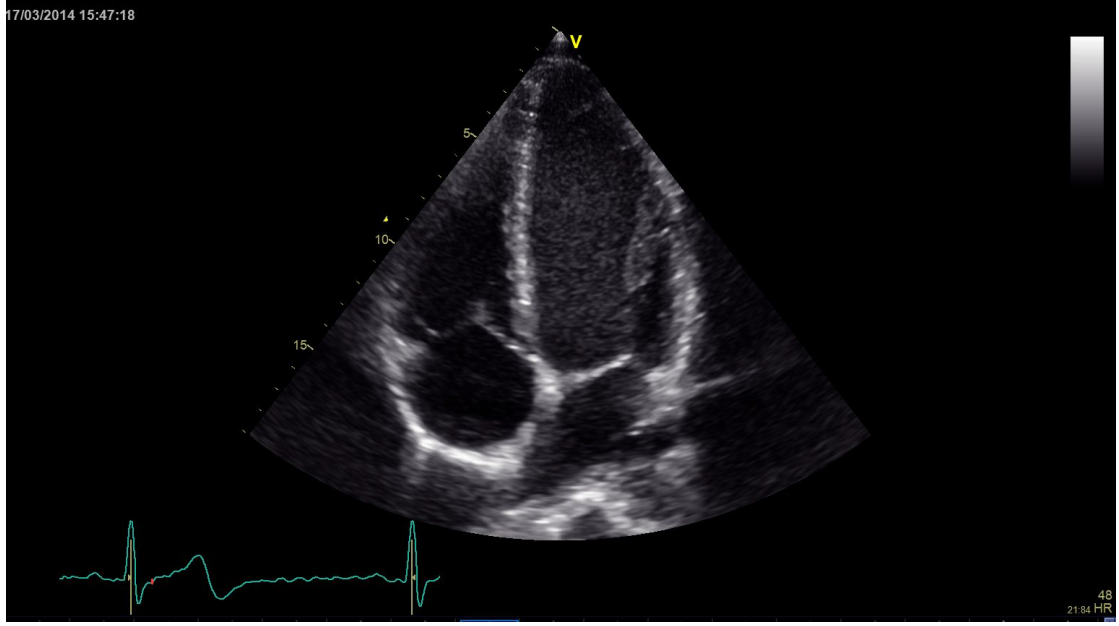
B-Mode grayscale image from a healthy volunteer. Apical 4-chamber acquisition.
